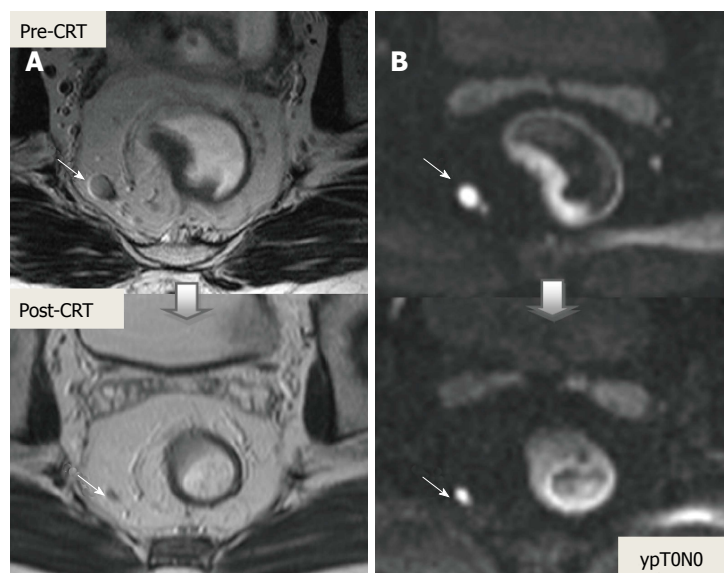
On diffusion-weighted imaging, false-positive mesorectal lymph node evaluation after chemoradiotherapy in ypT0N0 rectal cancer. A: T2-weighted axial magnetic resonance images show significant diminution in nodal size after chemoradiotherapy, compatible with negative lymph node (arrows); B: Diffusion-weighted images, high diffusion signal continues after treatment in the perirectal lymph node, compatible with positive lymph node (arrows). CRT: Chemoradiotherapy.
